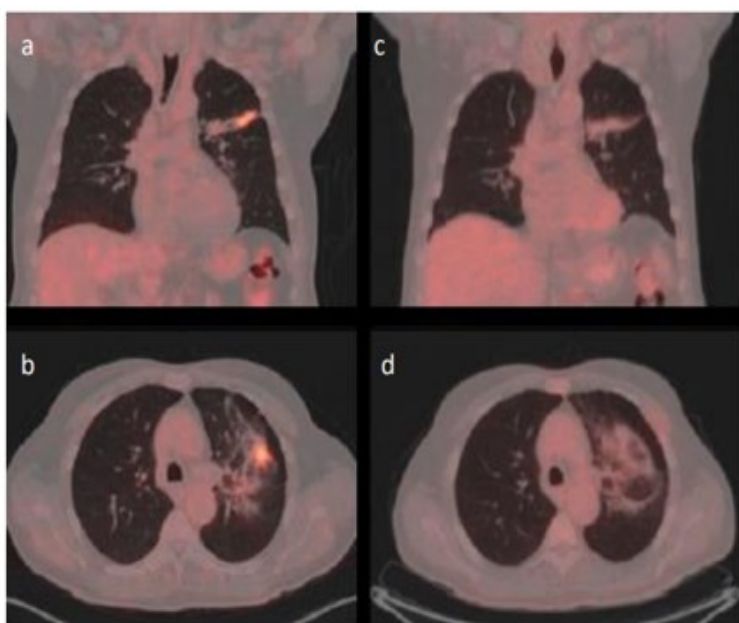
y.o male treated for the left NSCLC, follow up FDG PET images show complete metabolic response and only fibrosis/necrosis in irradiated area; Pre-treatment (a,b) and posttreatment fused PET/CT images (c,d).
